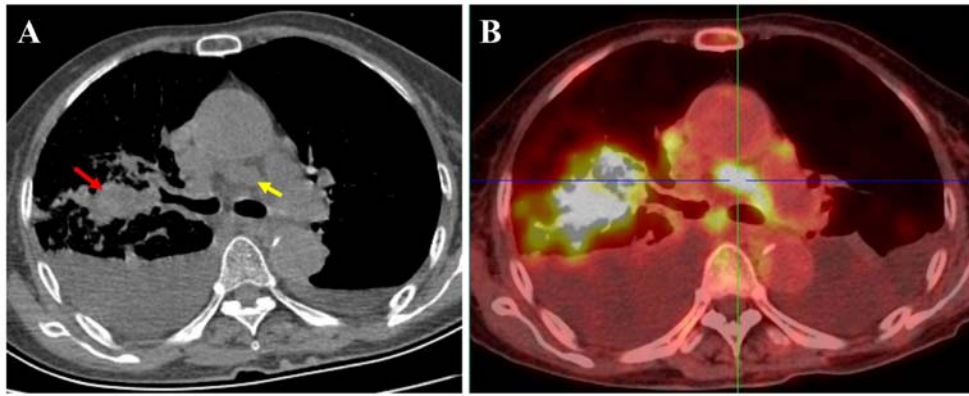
Diagnostic chest imaging. (A) Chest computed tomography scan showed a mass in the right upper lobe (red arrow) and enlargement of mediastinal lymph nodes (yellow arrow). (B) Positron emission tomography revealed a lung mass with a SUVmax of 24.7 and enlarged mediastinal lymph nodes with a SUVmax of 15.9. SUVmax, maximum standardized uptake value.
